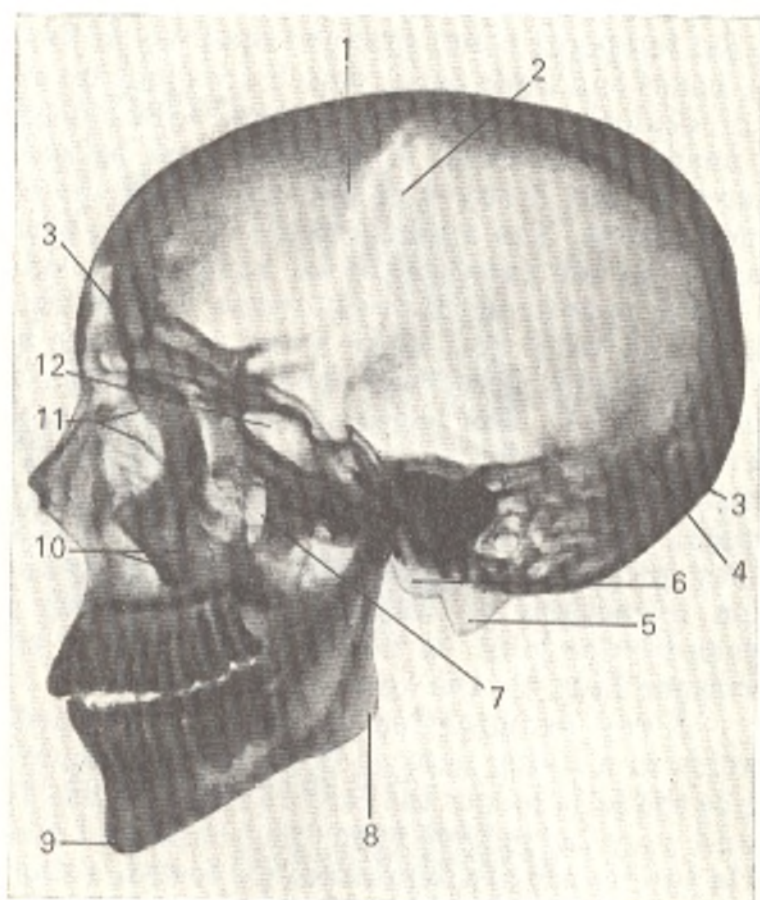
Radiograph of adult skull, lateral view.
